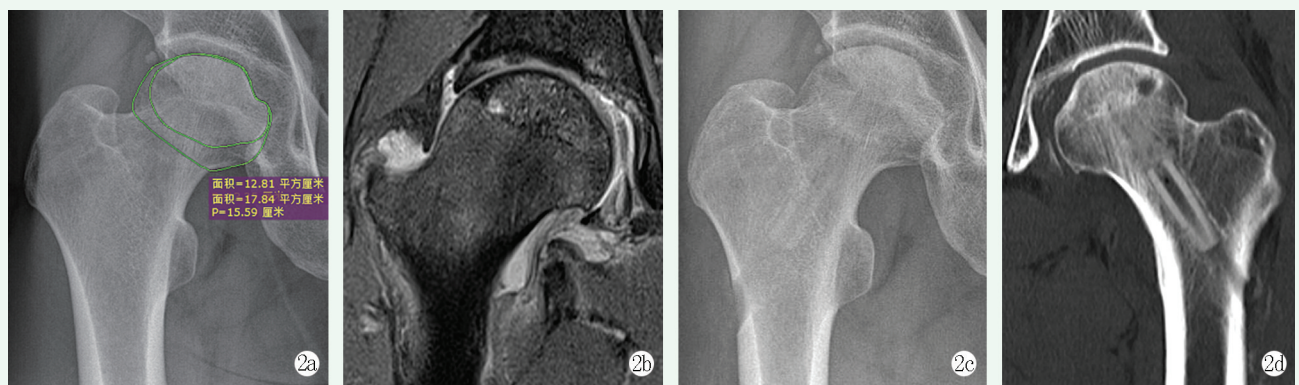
患者男性, 38 岁。2a: 术前 X 线片示右侧股骨头形状规则圆滑, 未见股骨头塌陷, Tönnis 分级 I 级; 2b: 术前 MRI 可见 T2 像下股骨头坏死区域呈混杂信号改变, 符合股骨头坏死 ARCO IIC 期; 2c: 髓芯压着植骨后末次随访 X 线片未见股骨头塌陷, 骨隧道及重建棒影; 2d: 末次随访 CT 可见股骨头形状圆滑无塌陷。
